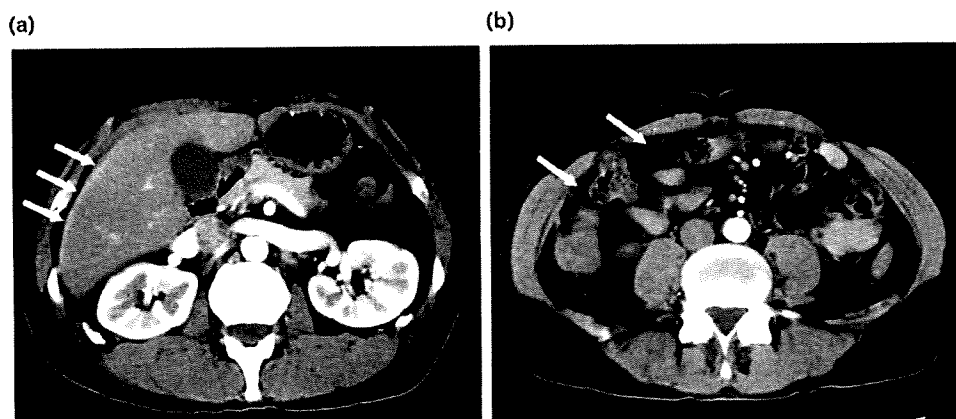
A computed tomography scan performed 11 days after the onset of the symptoms. A computed tomography scan shows contrast enhancement around the liver surface (a) and fatty stranding of the greater omentum (b).
